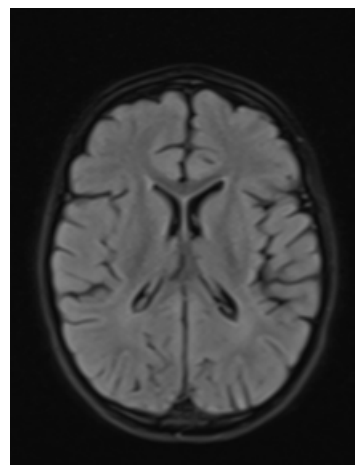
Diffusion-weighted MRI showing no restricted diffusion in the cerebral and cerebellar regions.
